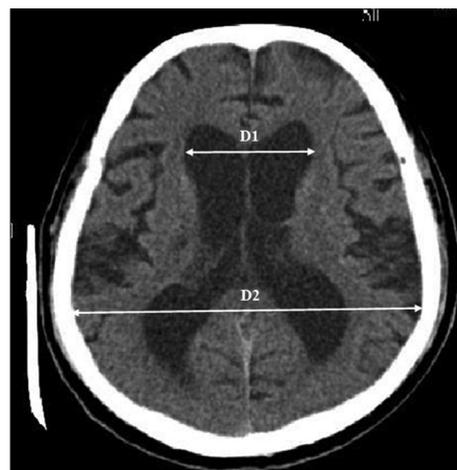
Computed tomogram of the brain without contrast showed enlargement of ventricles with mild cortical sulci widening over the frontal and the temporal lobe. The Evan's index, the ratio of D1 and D2, was 0.33, suggesting the possibility of normal pressure hydrocephalus. D1, the width of the frontal horns of the lateral ventricles; D2, maximum internal diameter of the skull.
